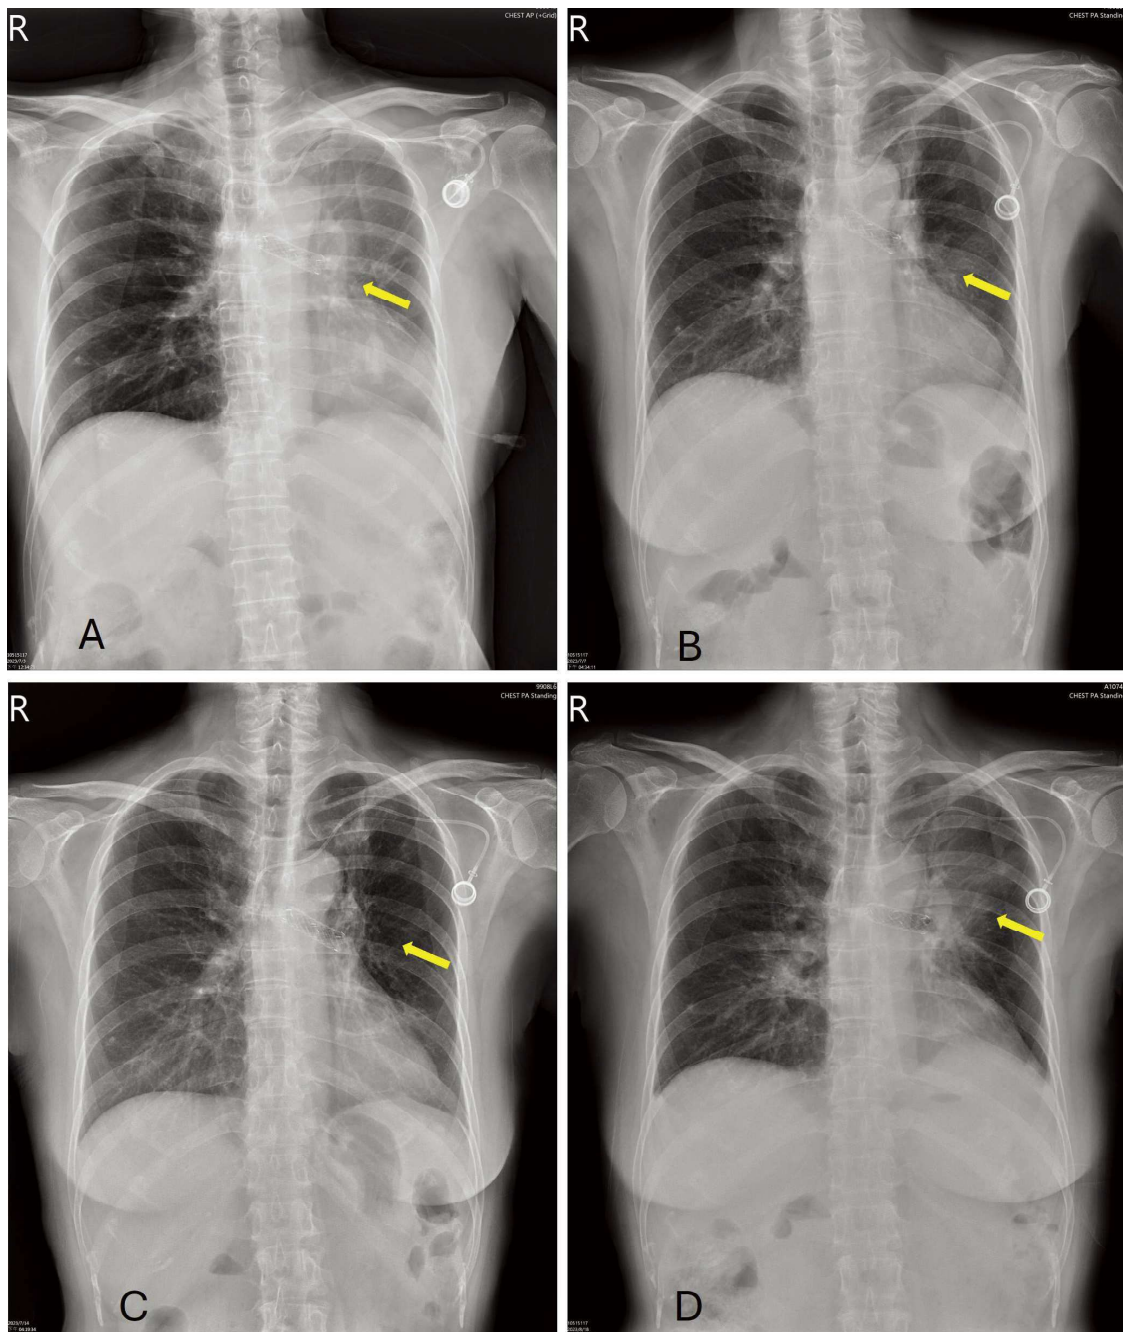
Series of follow-up chest X-rays (CXR), as follows: (A) Post-stenting in the left bronchus, with suspected re-expansion of the obstructive left lung. (B) Stable lung cancer in the left upper lobe (LUL) with lung-to-lung metastasis. (C) One-week outpatient follow-up; minimal change in LUL lung cancer with lung-to-lung metastasis. (D) Nearly 2 months later, suspected progression of lung cancer with signs of obstructive pneumonitis.
